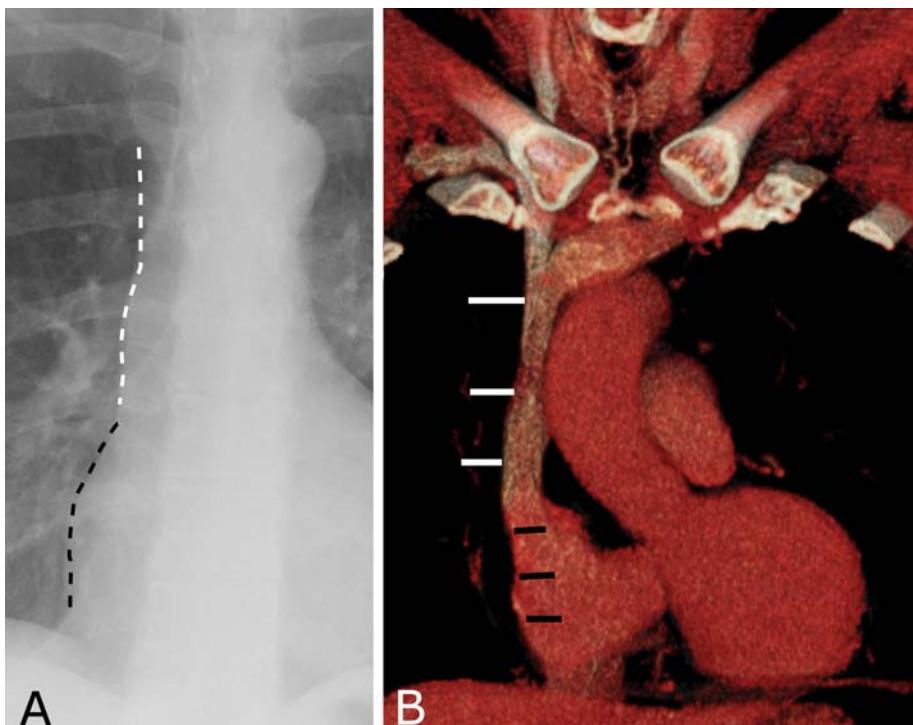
Right mediastinal border. A. Frontal radiograph shows the superior vena cave (white dashes) descending and joining with the right atrium (black dashes). B. Volume rendered CT shows the same structures with white and black lines, respectively. Notice that the ascending aorta does not contribute to the right heart border in normal patients (though in patients with a very ectatic or aneurysmal aorta it can extend lateral to the SVC and form the right mediastinal border).
